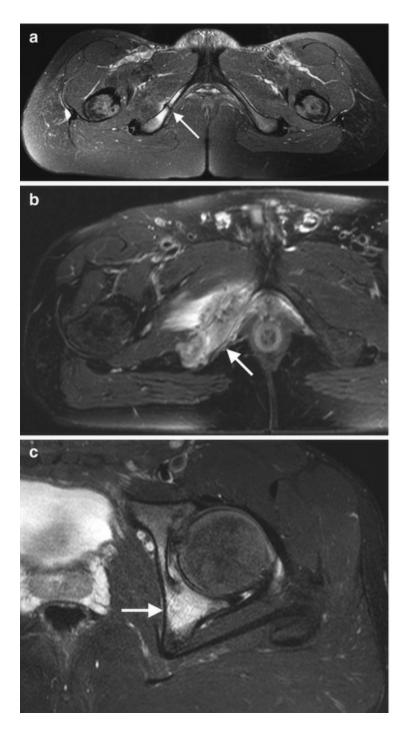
Examples of differential diagnoses of pain that may suggest damage to a short external rotator muscle of the hip on these axial fat-suppressed T2-weighted MRI. (a) A 34-year-old woman triathlete with onset of pain during competition. Fatigue fracture of the right ischiopubic ramus (white arrow). (b) A 45-year-old male runner, with a pathological fracture of the ischiopubic ramus (white arrow) on a metastasis of prostate cancer. (c) A 17-year-old football (soccer) player with aseptic acetabular osteomyelitis (white arrow)
